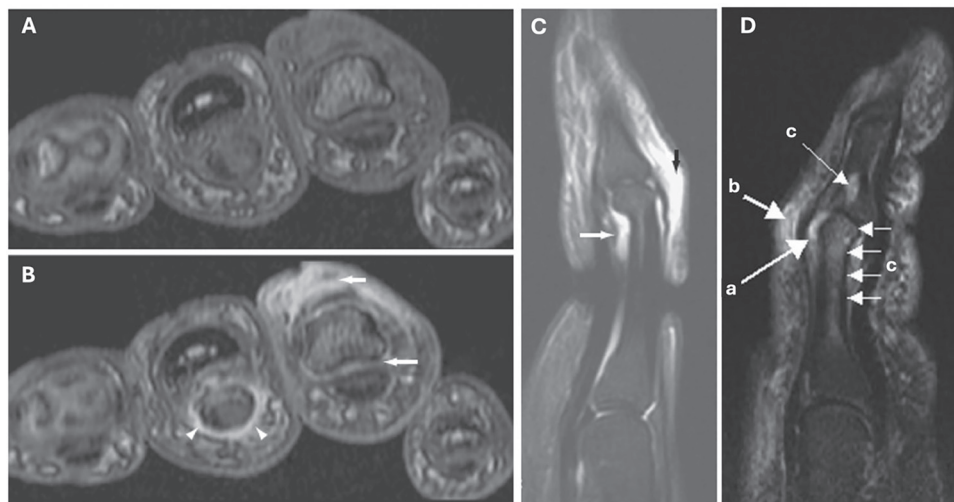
Example of inflammatory manifestations observed in a patient with psoriatic arthritis using magnetic resonance imaging of the hands. Left: Axial T1-weighted images (A) before and (B) after intravenous contrast injection. Arrowheads show tenosynovitis, whereas arrows show synovitis and periarticular inflammation. Middle: Sagittal STIR image of a finger showing synovitis (white arrow) and periarticular inflammation (black arrow). Right: (D) Sagittal STIR image of a finger showing (a) synovitis, (b) periarticular inflammation, and (c) bone marrow edema. Modified with permission from Østergaard et al.²³ STIR: short-tau inversion recovery.
